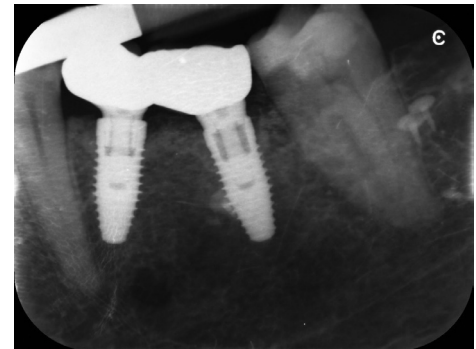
Peri-apical x-ray at 5-year follow-up.
